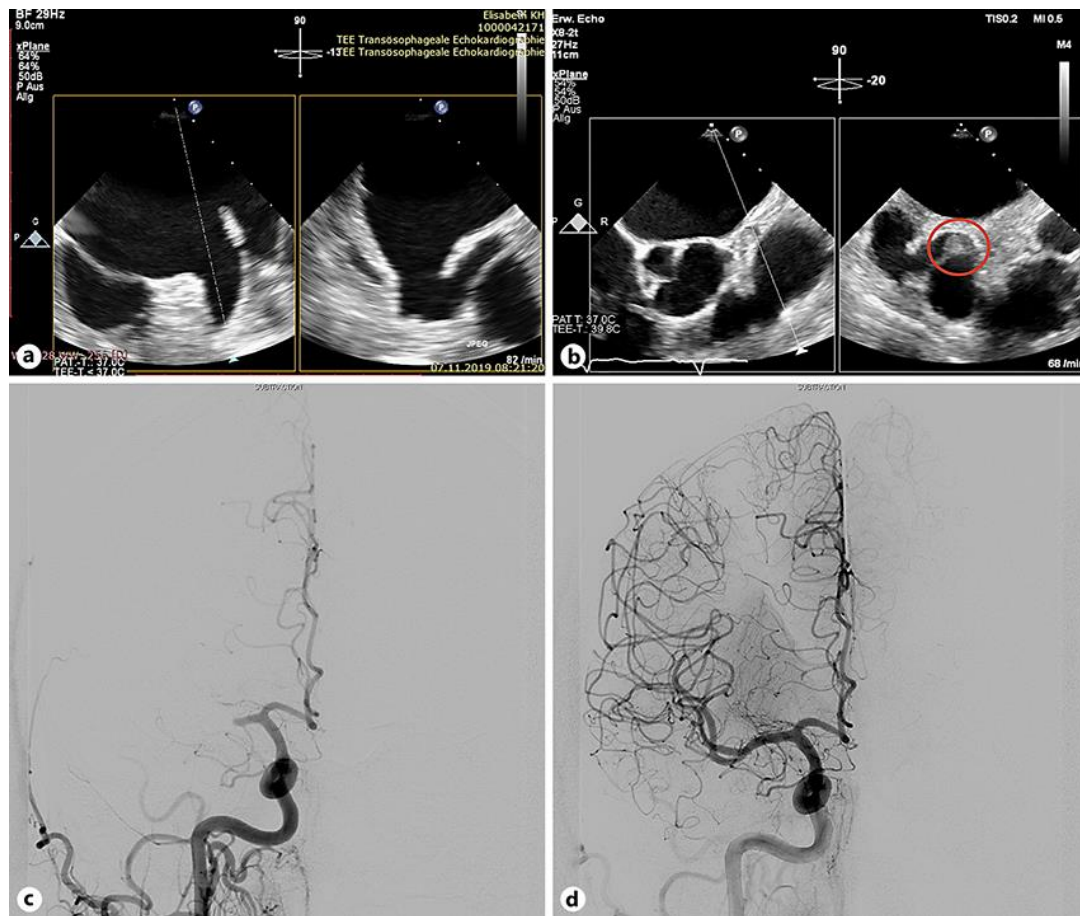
Ultrasound and angiography images. a Images from transesophageal echocardiography directly prior to cardiac intervention depicting no pathological structure. b Images from transesophageal echocardiography 5 days after stroke showing a thrombus (approx. 1.4 × 0.6 cm) in the left atrial appendage. c, d Angiography images before (c) and after (d) mechanical thrombectomy of proximal M1 occlusion with one stent-retriever assisted vacuum-locked extraction (SAVE) resulted in successful reperfusion (TICI grade 2b).
